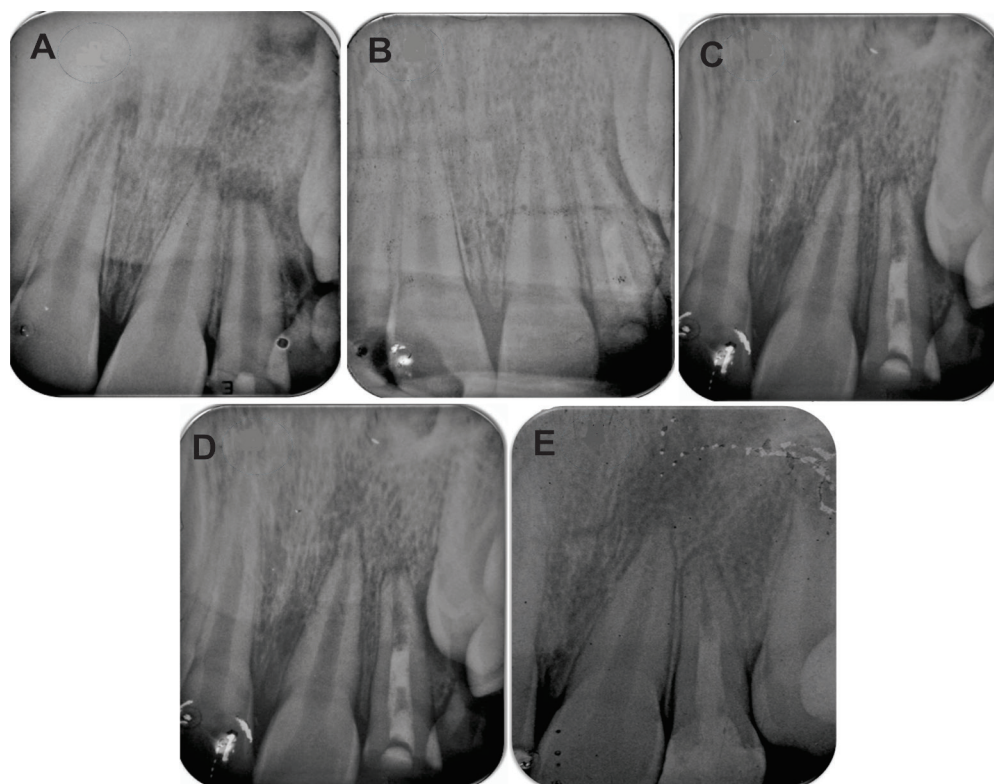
A) Initial radiograph showing periapical lesion and incomplete rhizogenesis. B) 15 days after - regression of the periapical lesion, corresponding to the period in which the mass remained uncondensed, and the middle third filled with MTA in left lateral incisor (n=10). C) Control of 3 months - beginning of the hard blade design and deposition of tissue in the Apical region. D) Control of 1 year - reduction of the lumen of the conduit and thickening of the root walls. E) 2 years - complete apical closure showing increased tissue deposition and thick walls, hard blade delineation and complete regression of the lesion.
